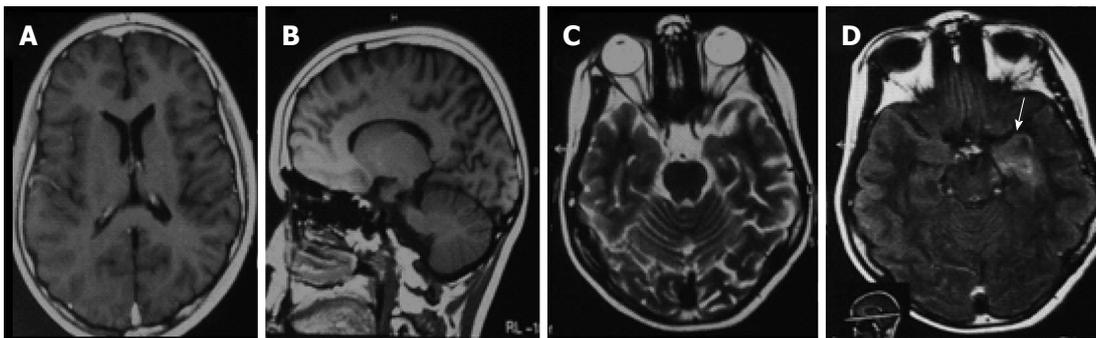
Cranial magnetic resonance imaging brain (September 2010) showing (A, B) normal axial and sagittal T1W and (C) axial T2W images but (D) hyperintense lesion in the antero-medial region of the left temporal lobe (white arrow) in fluid attenuated inversion recovery image.
